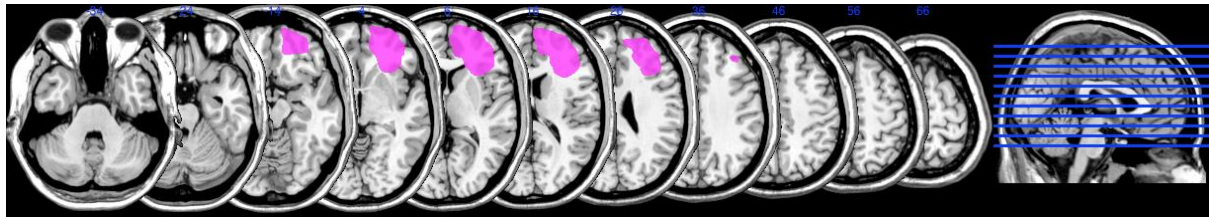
MRI scan of patient GP
